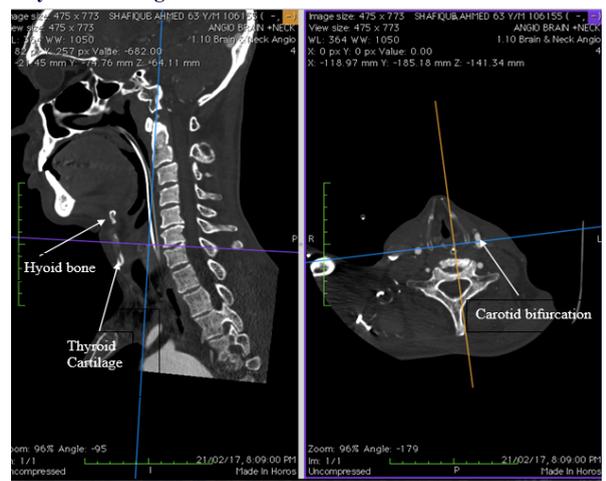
Sagittal and axial sections on CT angiogram depicting bifurcation of common carotid artery at the level of Hyoid Bone
